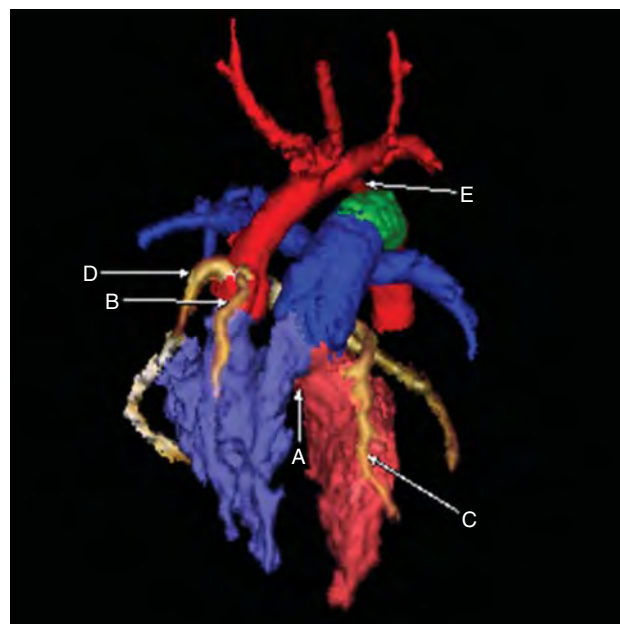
A frontal and posterior projection from a 3D color-coded cardiac CT in a patient with transposed double outlet right ventricle. Notice that the right ventricle (purple) gives rise to the aorta (red) and contributes to the main pulmonary artery (blue). A subpulmonic ventricular septal defect (VSD) (A) is shown. The descending aortic arch is hypoplastic (E). A PDA (green) is widely patent and needed to get enough blood to the descending aorta. An accessory LAD (B) originates from the right coronary sinus adjacent to the origin of the right coronary artery (D). The LAD (C) originates from the left coronary artery.
